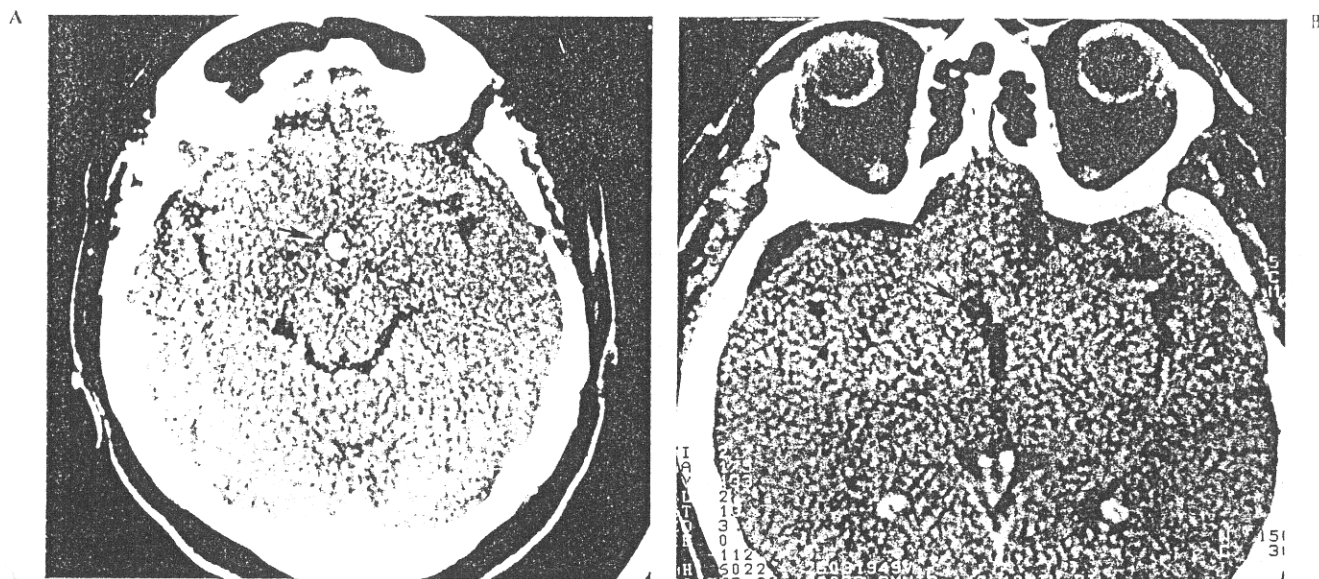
A: Preoperative CT scan of the case as shown in Figs. 17–20 showing the calcified tumor (arrow). B: Postoperative CT-scan of the same case [note the hypodensity at the former site of the calcified tumor (arrow)].
